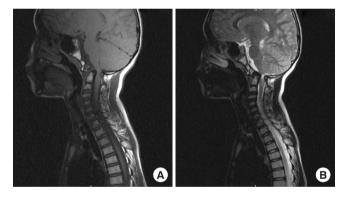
(A, B) Sagittal T1- and T2-weighted sequences showing significant compression of the cord at the craniocervical junction with intramedullary signal changes.
